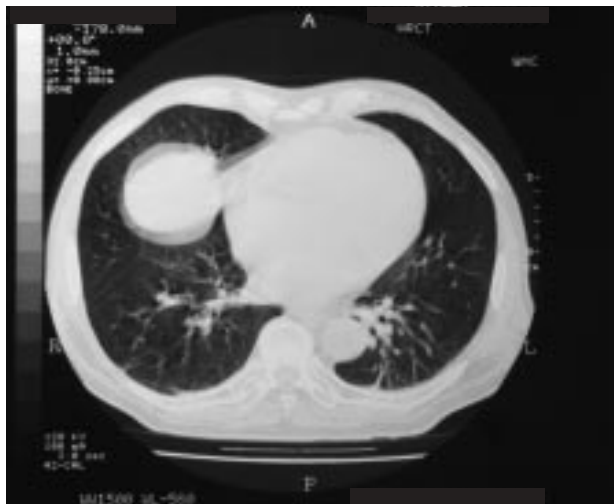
Discharge chest CT scan. Significant clearance of the changes described above.
